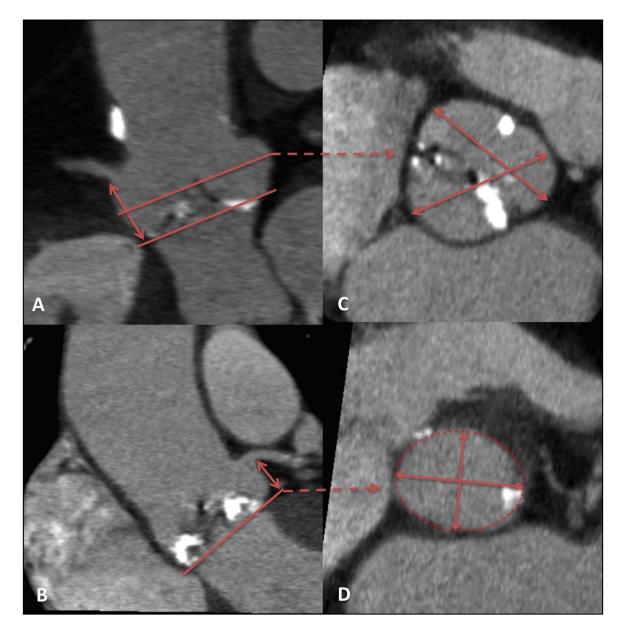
Multidetector computed tomography evaluation pre-TAVI
